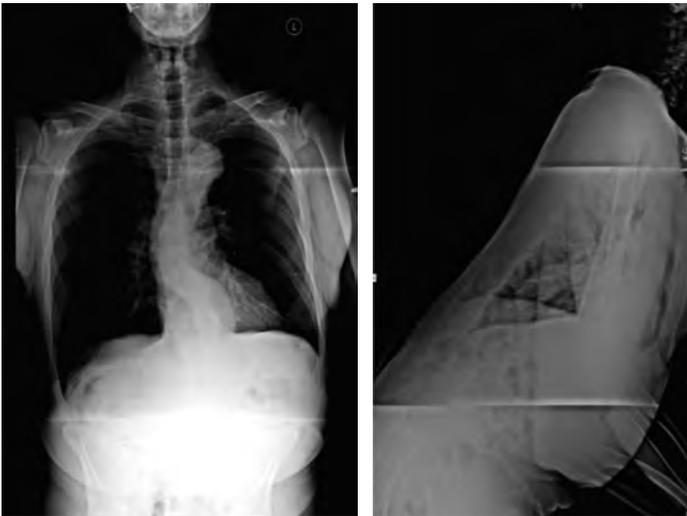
Pre operative radiographs. Note significant positive sagittal balance.
